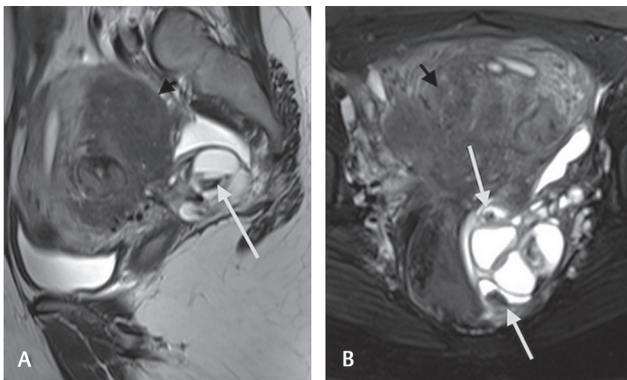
(A, B) T2W sag (A) and T2W FS axial (B) images showing hypointense nodular areas along the periphery of the endometriomas (arrow)—“T2 dark spot.” Note is also made of a large deep endometriotic deposit in the posterior uterine myometrium (arrowhead). FS, fat-suppressed; T2W, T2-weighted.
